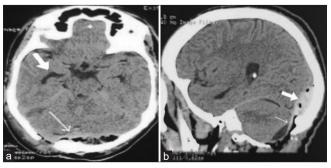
(a) Postoperative axial computed tomography (CT) scan head on day 1 showing evacuated Epidural hematoma (EDH) (thin arrow) and decrease in size of ventricles (thick arrow) (b) postoperative sagittal CT scan head showing evacuated infratentorial EDH (thin arrow) and a small amount of residual blood (thick arrow).
